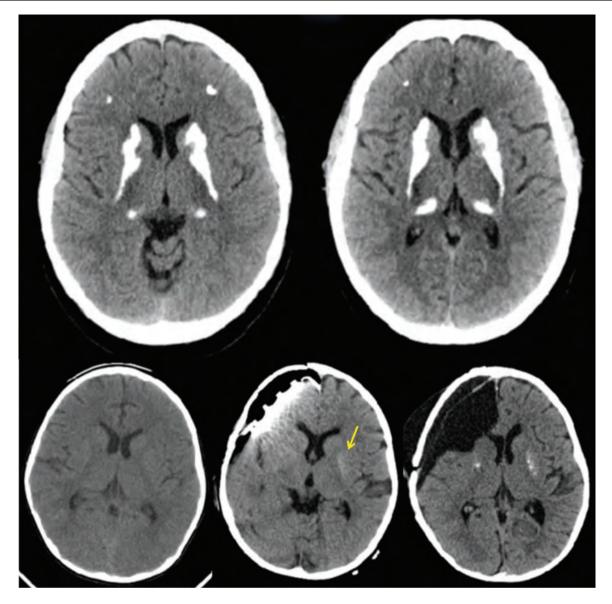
The upper 2 panels show apparent stability of BGC over 11 years in a 59-year-old patient with familial hypoparathyroidism. The 3 bottom panels show the onset of basal ganglia calcification in a 25-year-old patient with autoimmune hypoparathyroidism and lobectomy due to a brain tumor who had three head CT scans performed over 13 years.
